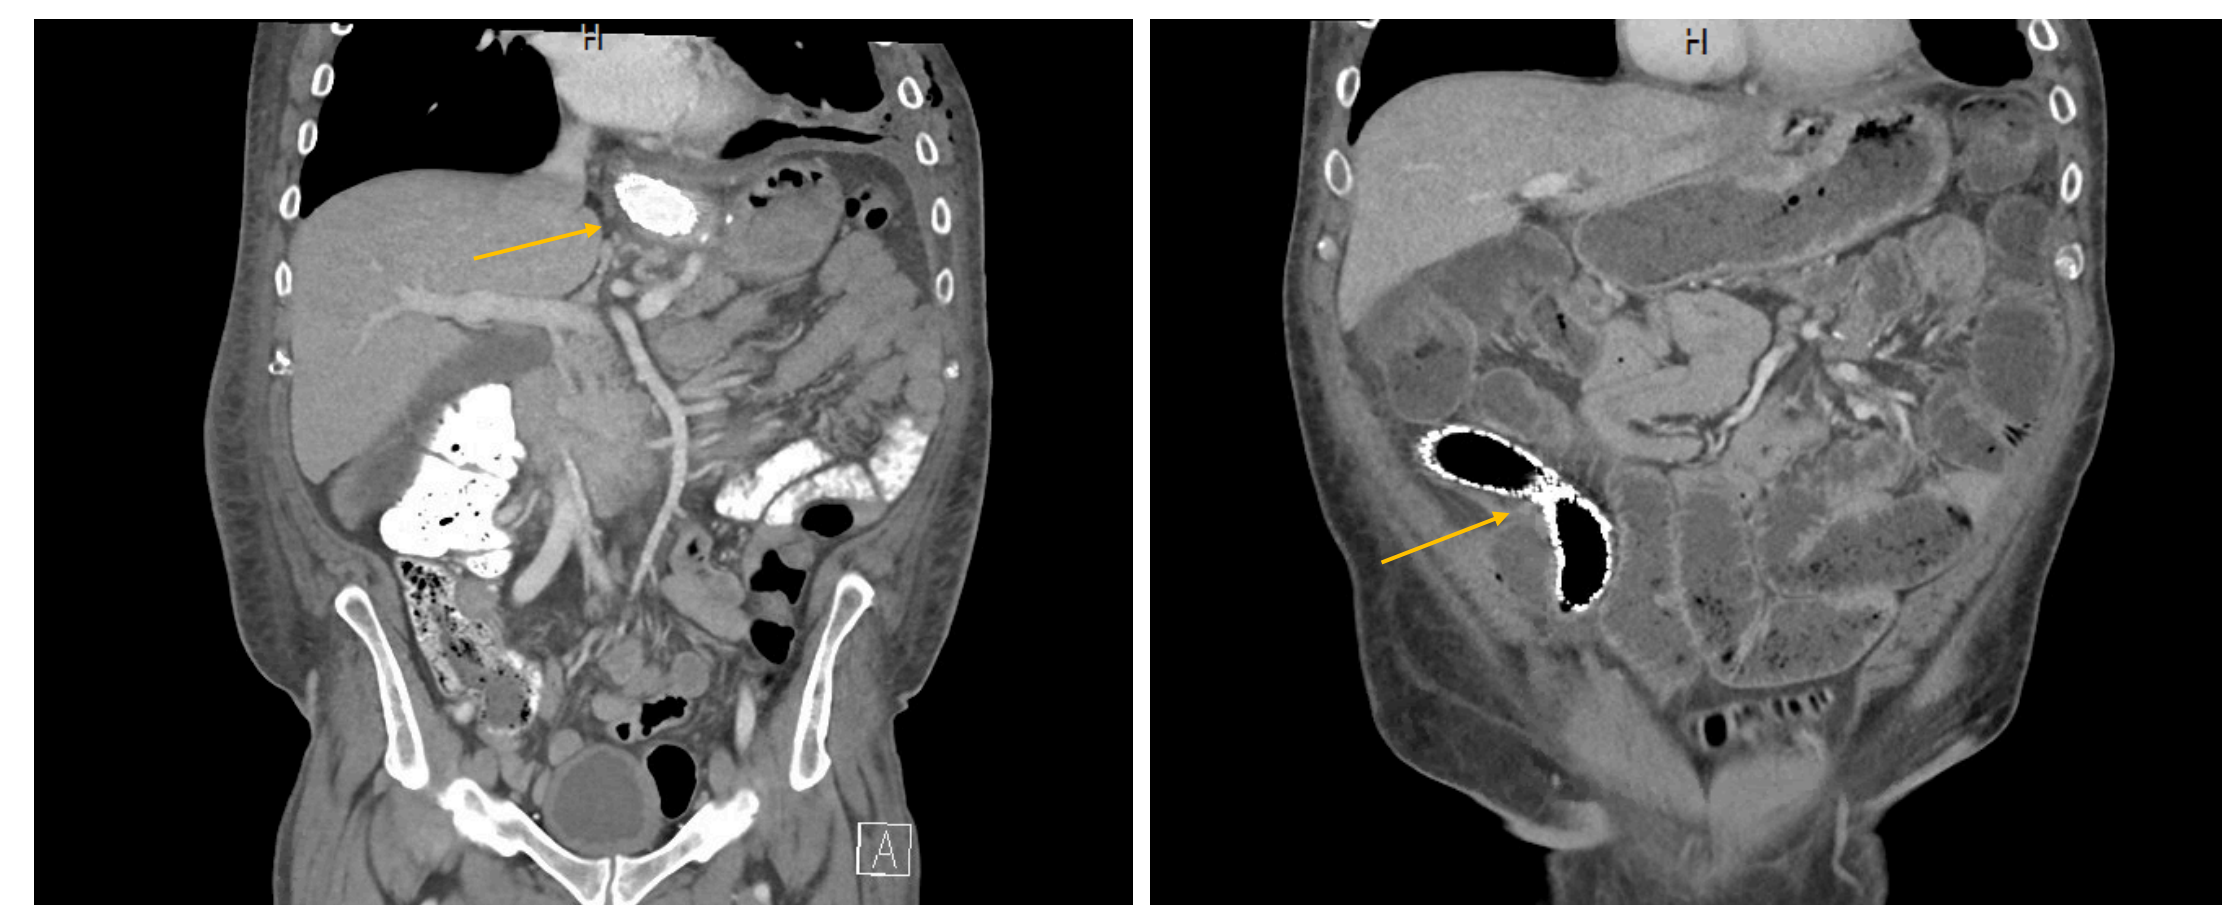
CT abdomen and pelvis with IV and oral contrast (6/28/2022). Arrow indicates stent overlying the GJ junction with no extravasation of contrast.
